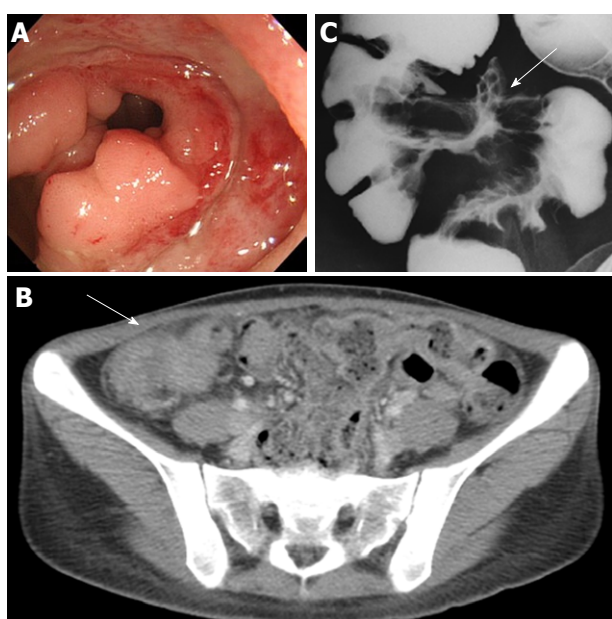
Behçet's disease in a 25-year-old woman with abdominal pain and diarrhea. A: Colonoscopy showed a large punched-out ulcer with elevated margins in the terminal ileum; B: Contrast-enhanced computed tomography scan of the abdomen showed a mass-like lesion with unevenly thickened bowel wall of the ileocecal region (arrow); C: Small bowel barium radiography disclosed the large ulcer (arrow) with convergence of mucosal folds in the terminal ileum.
